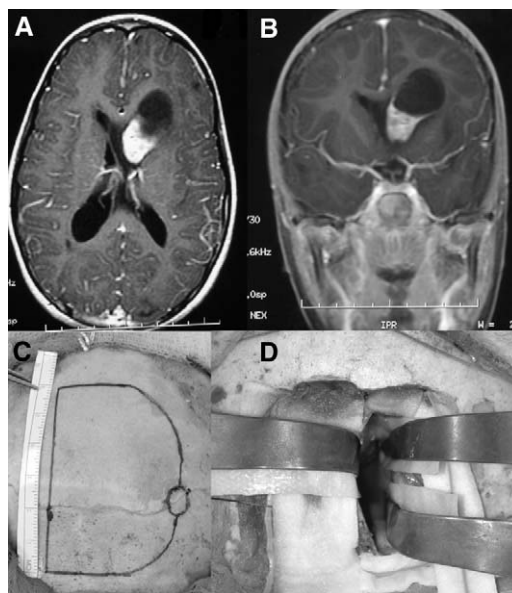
T1-weighted axial (A) and coronal (B) MRI with contrast demonstrates an enhancing mass in the left lateral ventricle that was resected via an anterior transcallosal approach. (C) Intraoperative photograph demonstrating the size and position of the bone flap for this approach. (D) Intraoperative photograph showing the use of three self-retaining retractors (two laterally and one medially) to establish the interhemispheric corridor.
